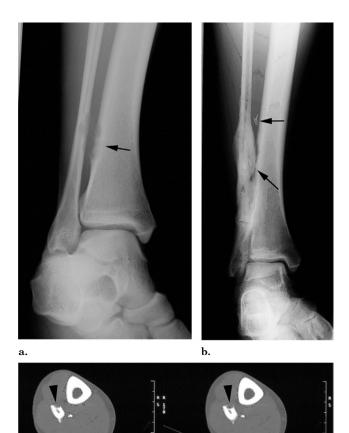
(a) Plain radiograph at initial presentation (9.5 y before the MR-guided biopsy described in the present report), before any treatment (lesion is indicated by the arrow). (b) Plain radiograph obtained 1 year after partial surgical resection; the arrows indicate surgical clips placed 7 y before MR-guided biopsy. (c) Noncontrast CT image obtained 2 years after surgery (5.5 y before MR-guided biopsy; arrowheads indicate the lesion).
